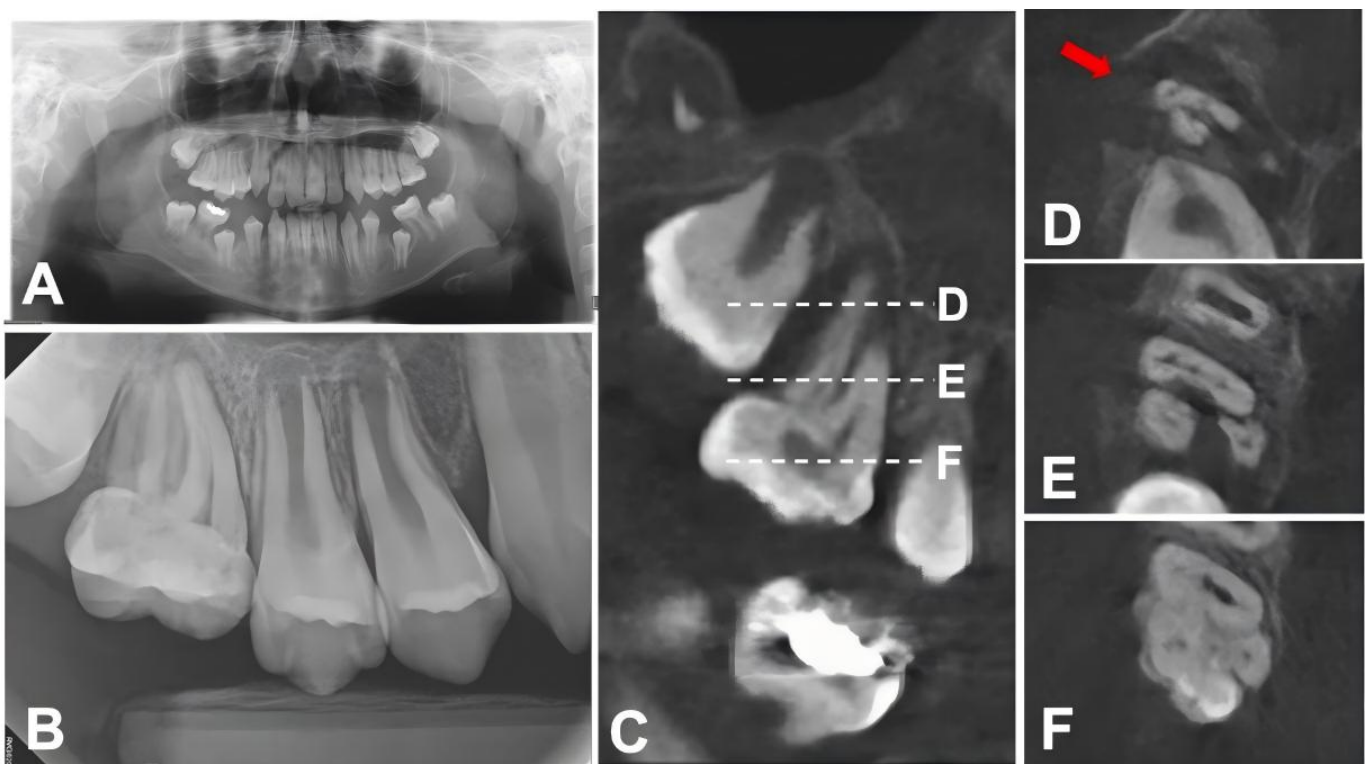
Preoperative Radiographs. (A) Initial panoramic radiograph. Molar-incisor malformation is evident in all maxillary and mandibular first molars. (B) Periapical radiograph showing apical periodontitis at the right maxillary first molar. (C) Sagittal CBCT view of the maxillary molar. Dashed lines D, E, and F indicate the respective levels of the apical, middle, and coronal axial image. (D) Axial CBCT image (apical area). The red arrow points to a large periapical lesion. (E) Axial CBCT image (middle area). The CBCT image reveals six canals: three mesiobuccal, two palatal, and one distobuccal. (F) Axial CBCT image (coronal area), showing complex internal anatomy.
